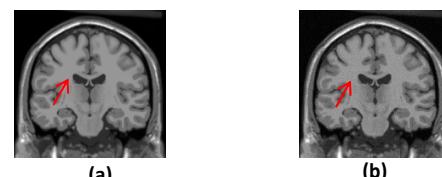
T1-weighted image (a): noiseless (b): noisy
